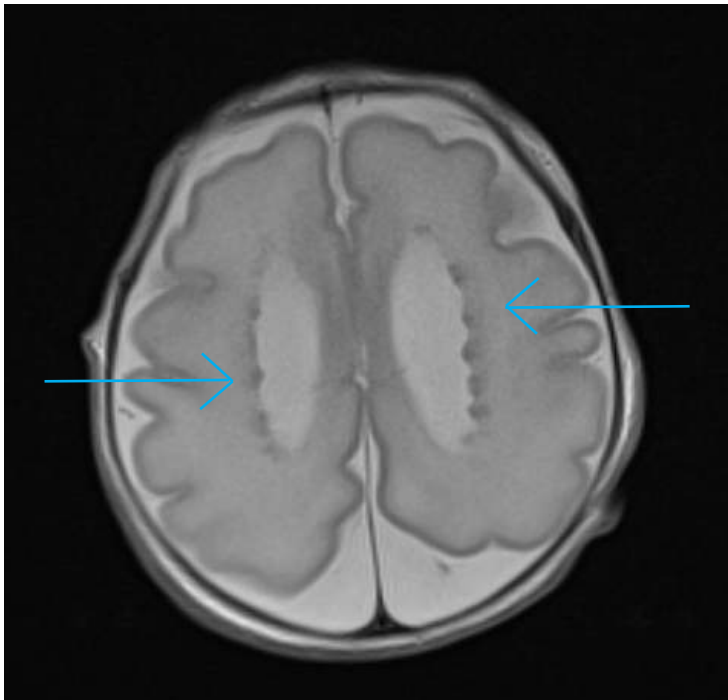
A, B. Brain MR imaging on day of life 28 shows A). an irregular and decreased gyral pattern with subependymal nodules (heterotopias) and B), enlarged cisterna magna and cerebellar hypoplasia.
